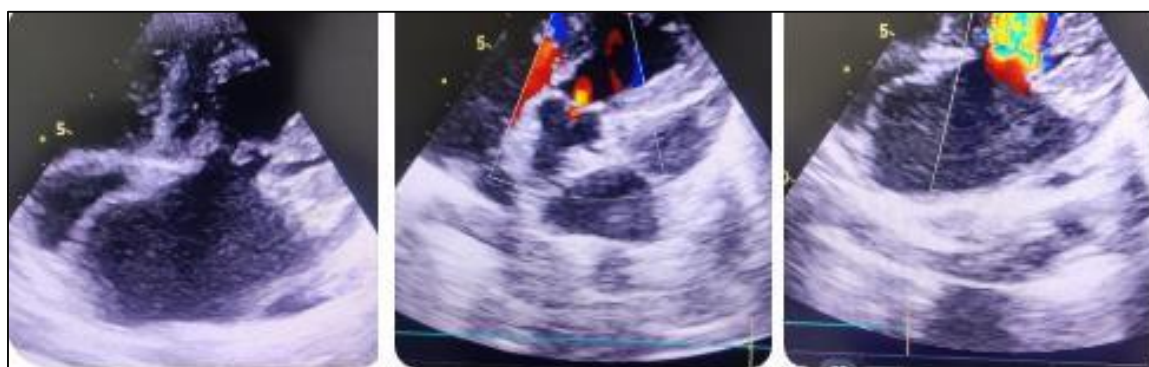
4C. A -Two-dimensional echocardiography showing thickened mitral valve leaflets with restricted motion. B-Color Doppler demonstrating turbulent. transmitral flow consistent with severe mitral stenosis. C- High-velocity Doppler jet across the mitral valve indicating significant obstruction.
